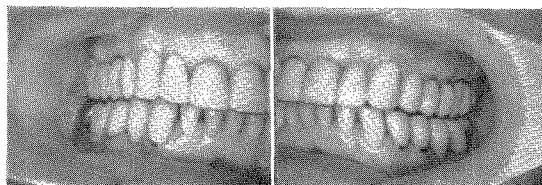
Right and left sides of the splint in the mouth. These photographs were taken in 1962. This was eight years after completion. The roentgenograms of the prosthesis shown in Figs. 396 and 397, just after completion, are shown in Fig. 997, p. 462.
